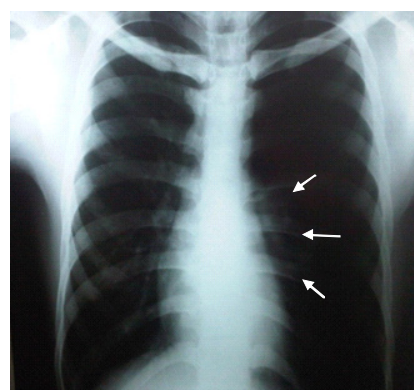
First Chest X-Ray (arrows pointing pleural line)
